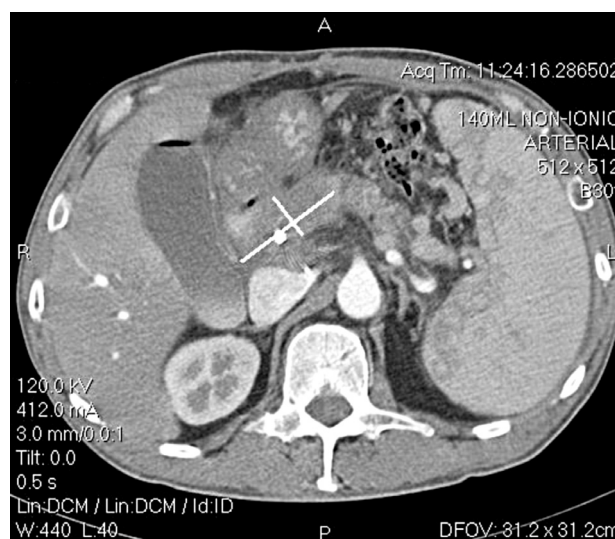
A CT image showing asymmetrical pancreatic head mass measuring 41 × 19 mm. On follow-up imaging study it was classified as progressive disease based on RECIST. However, when the WHO bi-dimensional criteria were applied, it was classified as stable disease. It is fairly obvious that aiming for millimeter accuracy would be futile in this lesion.
